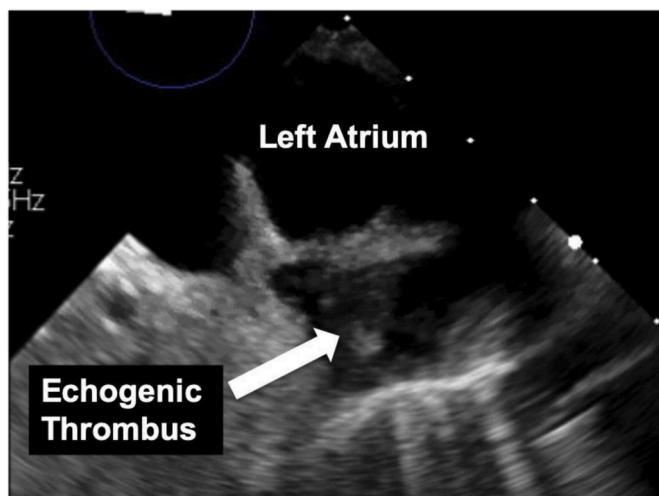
Trans*-esophageal echocardiogram demonstrates echogenic thrombus within the superior pulmonary vein.
